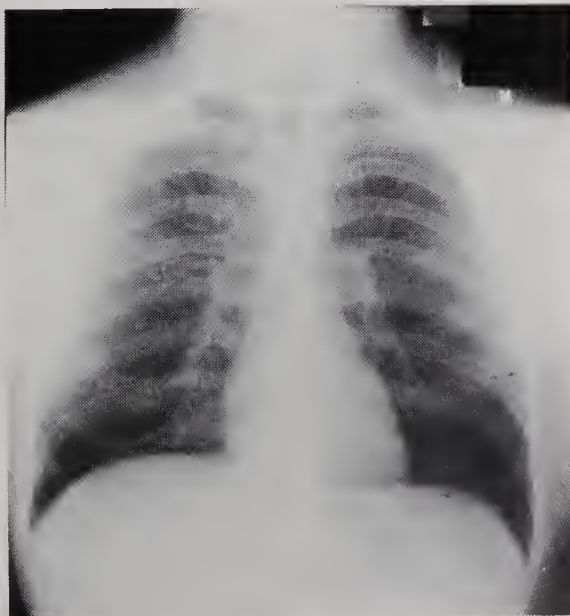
Chest roentgenogram 1 year after aspiration.
